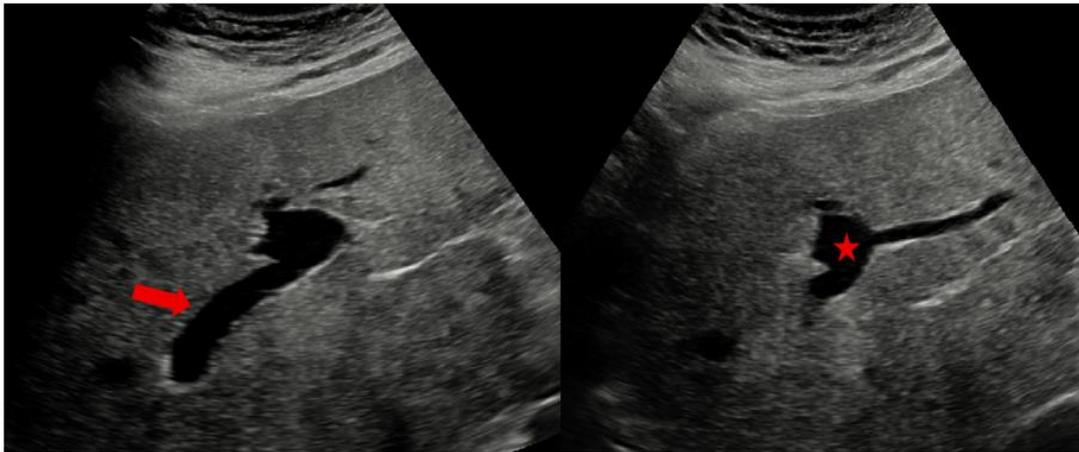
B-mode ultrasound image demonstrating saccular, anechoic structure (asterisk) located in the Rex recess between segments II and III. The image clearly shows the lesion's direct anatomical continuity with the left portal vein branch (arrow)
